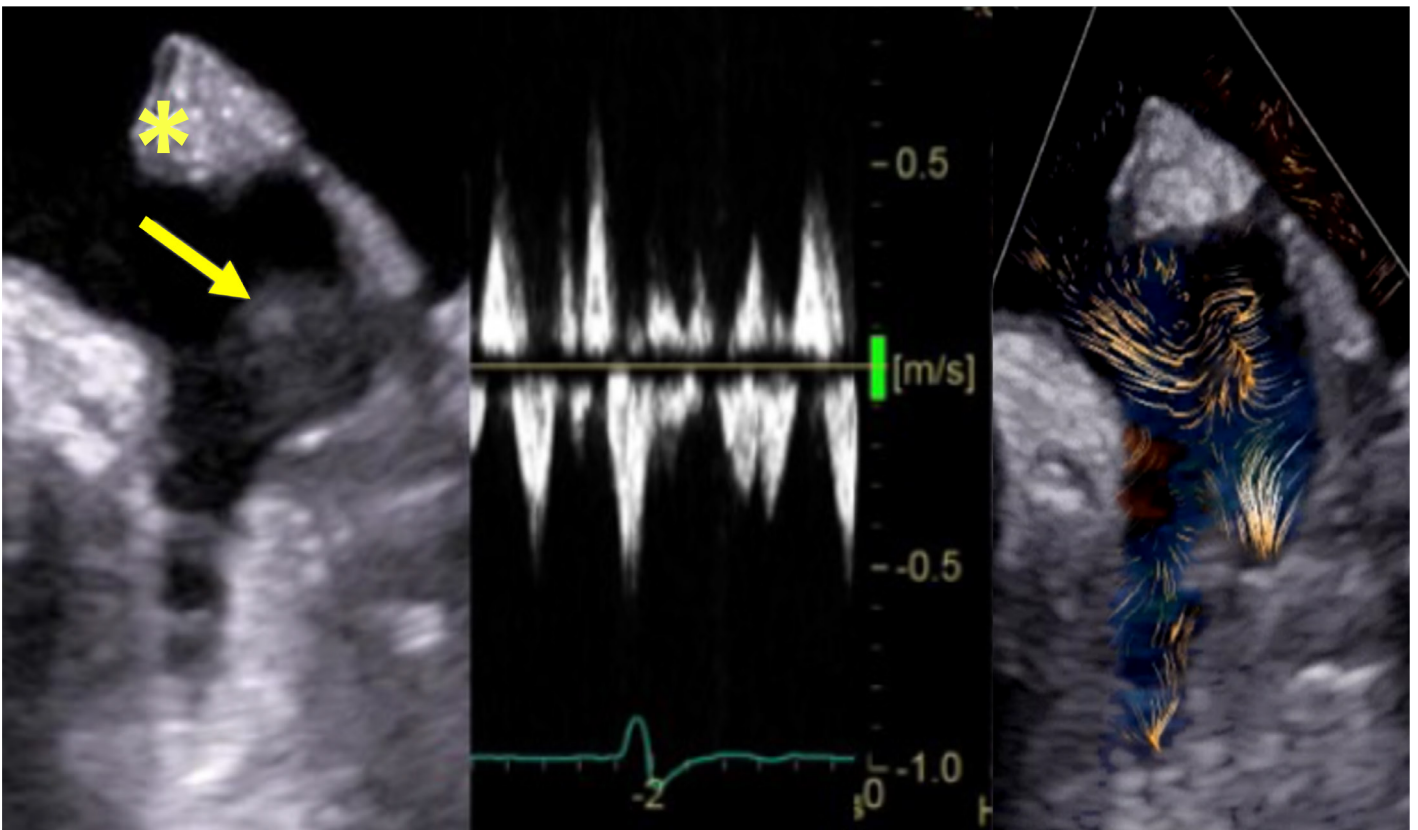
Bi-lobed left atrial appendage with thrombus-mimicking reverberation artifact (left, arrow) from prominent Coumadin ridge (*) but with normal flow velocities by pulsed-wave Doppler (center). Blood speckle imaging shows normal blood flow in the region of the artifact as well as in both lobes of the appendage (right) suggesting the absence of thrombus.
